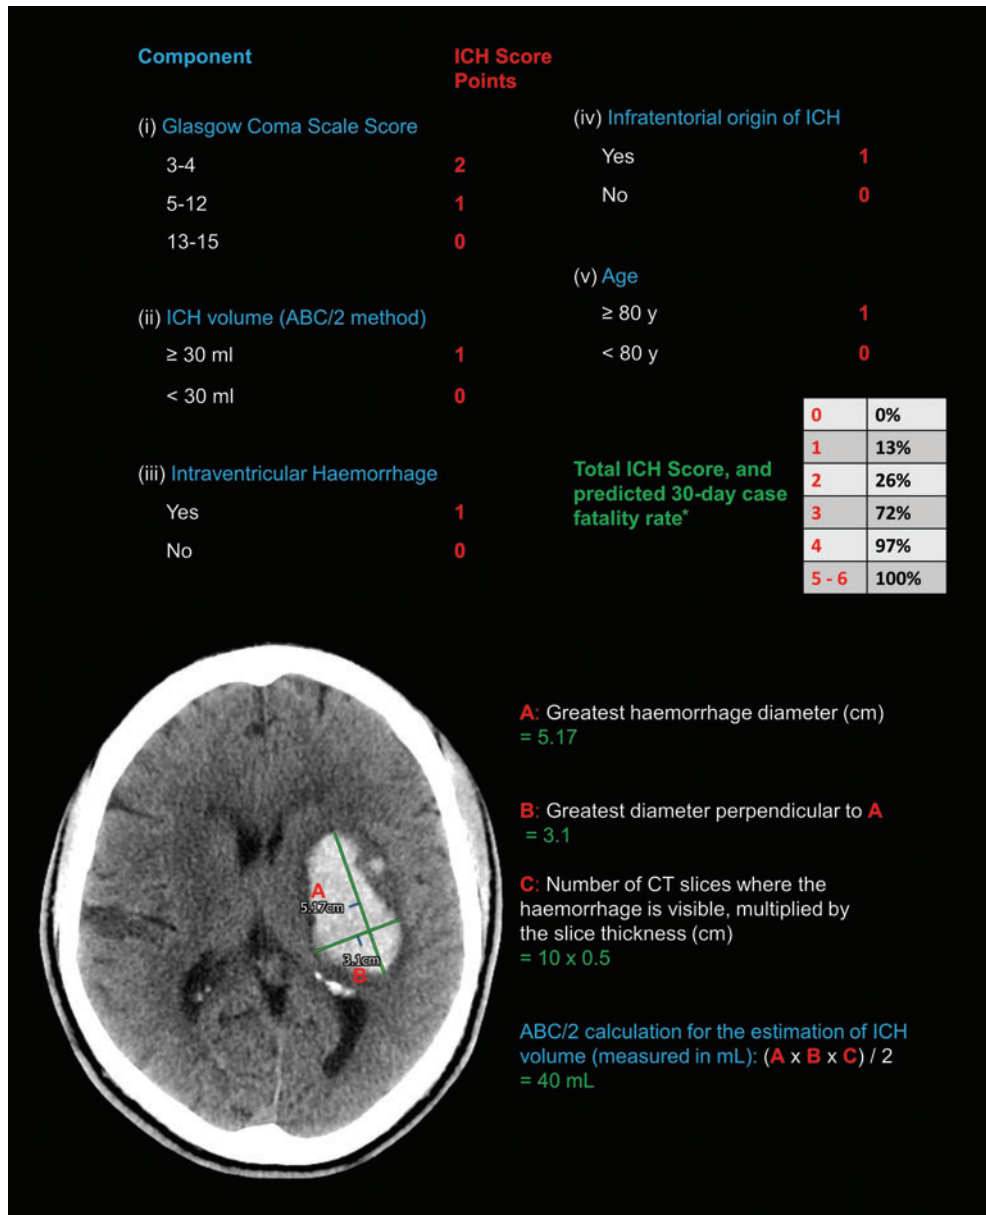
Upper panel: Calculation of the intracerebral haemorrhage score, a clinical grading scale and a useful communication tool. Predicted 30-day case-fatality rates are derived from the original validation study²²; *a subsequent study in which early do-not-resuscitate orders were not placed observed 30% lower mortality rates.²³ Lower panel: The use of the ABC/2 calculation (essentially the formula for the volume of an ellipsoid) to rapidly and accurately^{24 25} estimate the volume of an acute left-sided ganglio-capsular haemorrhage on non-contrast CT brain scan. (Copyright Iain McGurgan).
